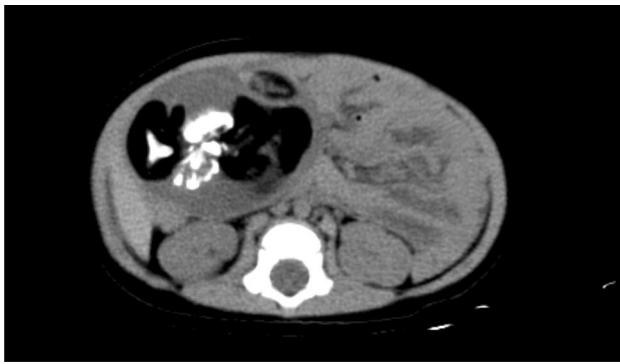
Abdominal computed tomography showed a well-defined sizable cystic tumor with focal calcification in the lower abdomen. Operative findings show an intraabdominal testicular tumor
